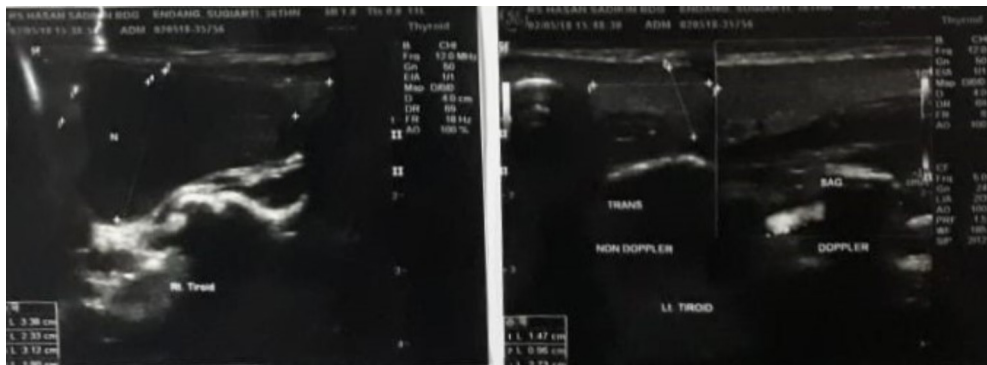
Ultrasonography showed a semi-solid mass in the right lobus: benign lesion (TIRADS 2)
